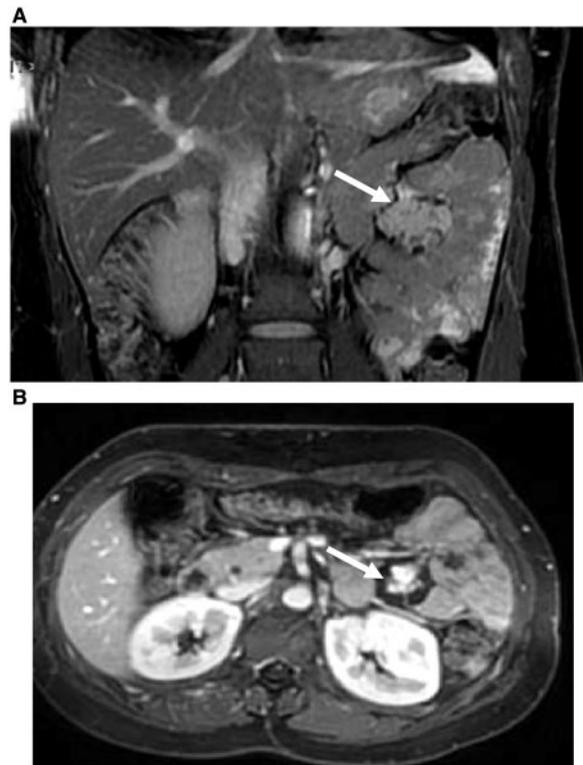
MR images of two different patients with ileal polyps. (A) Transverse true FISP sequence shows a soft tissue flat polyp (arrow), which appears moderately low in signal intensity, with no sign of bowel wall infiltration. (B) Coronal contrast T1-weighted fat-suppressed image shows intense enhancement of a polyp (arrow) with a slender stalk.
